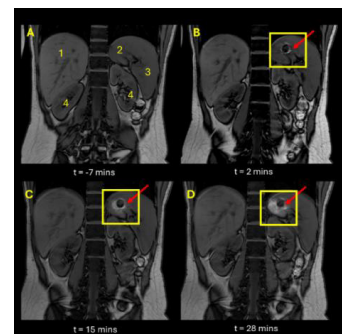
Coronal, T1-weighted Dual Echo MRI images of abdomen. Image A shows image after administration of nutritional drink and prior to tablet administration. Image B, C, D show participant at time points 2, 15 and 28 minutes respectively post tablet administration. Anatomical landmarks indicated in image A, liver (1), stomach(2), spleen(3), kidneys(4).
